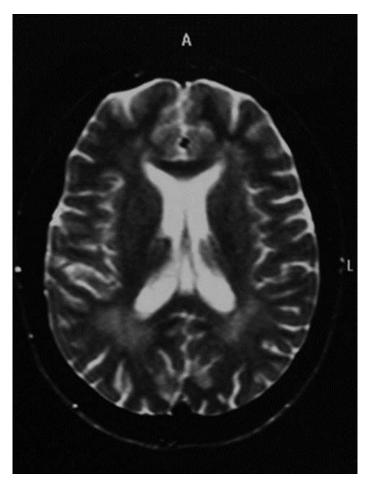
White matter abnormalities on the patient's axial MRI image.
